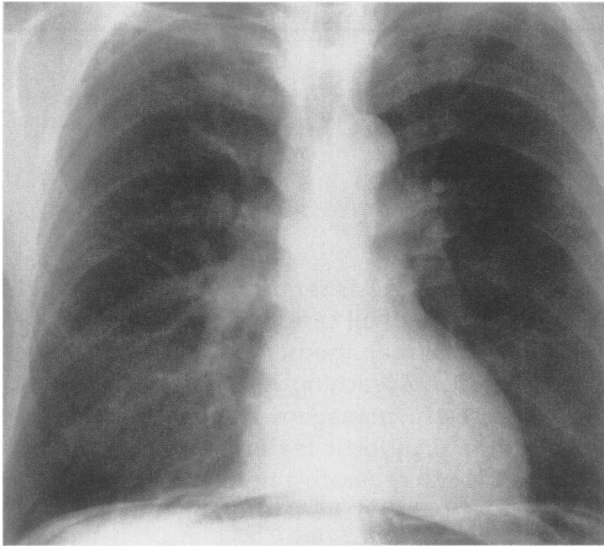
Chest radiograph demonstrates free intraperitoneal air (Patient 4).
